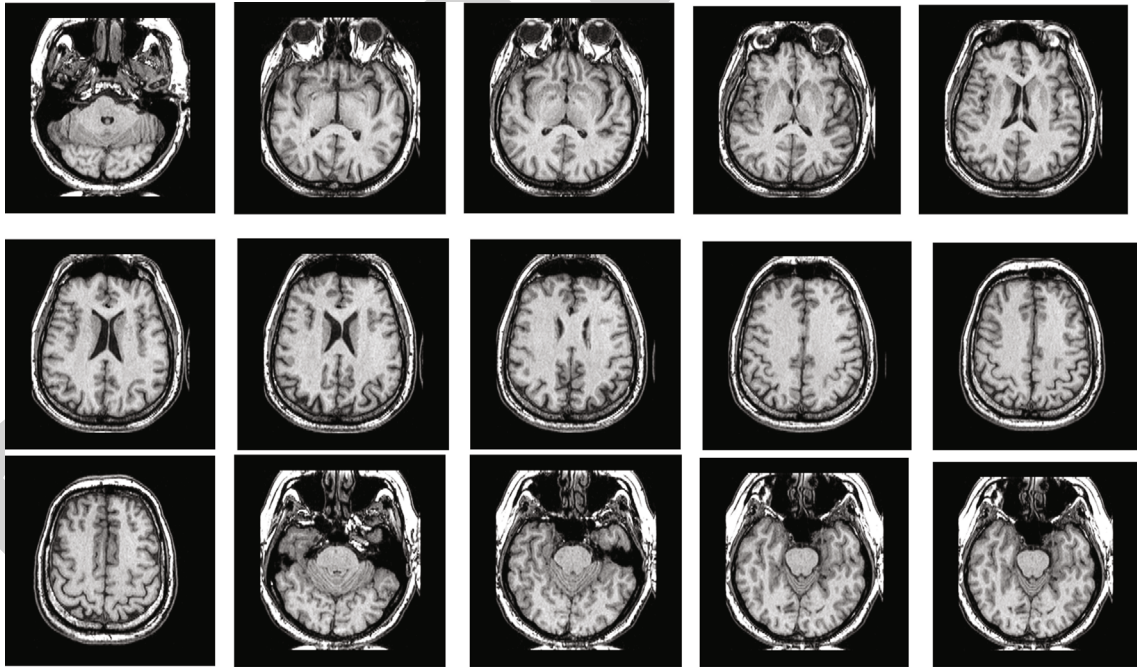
Sample MRI images from the dataset.
